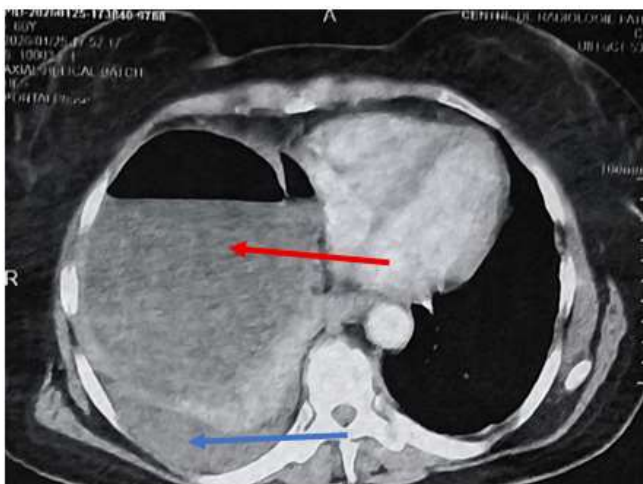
A CT scan showing the pleural effusion (blue arrow) associated with the interhepato-splenic abscess (Red Arrow)
